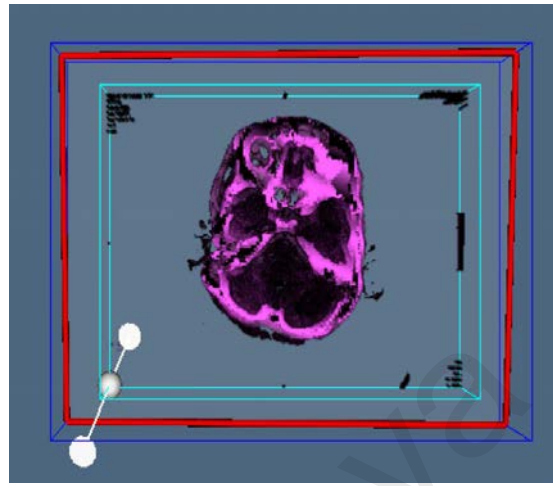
9 MRI brain volumetric rendering images from different angles
